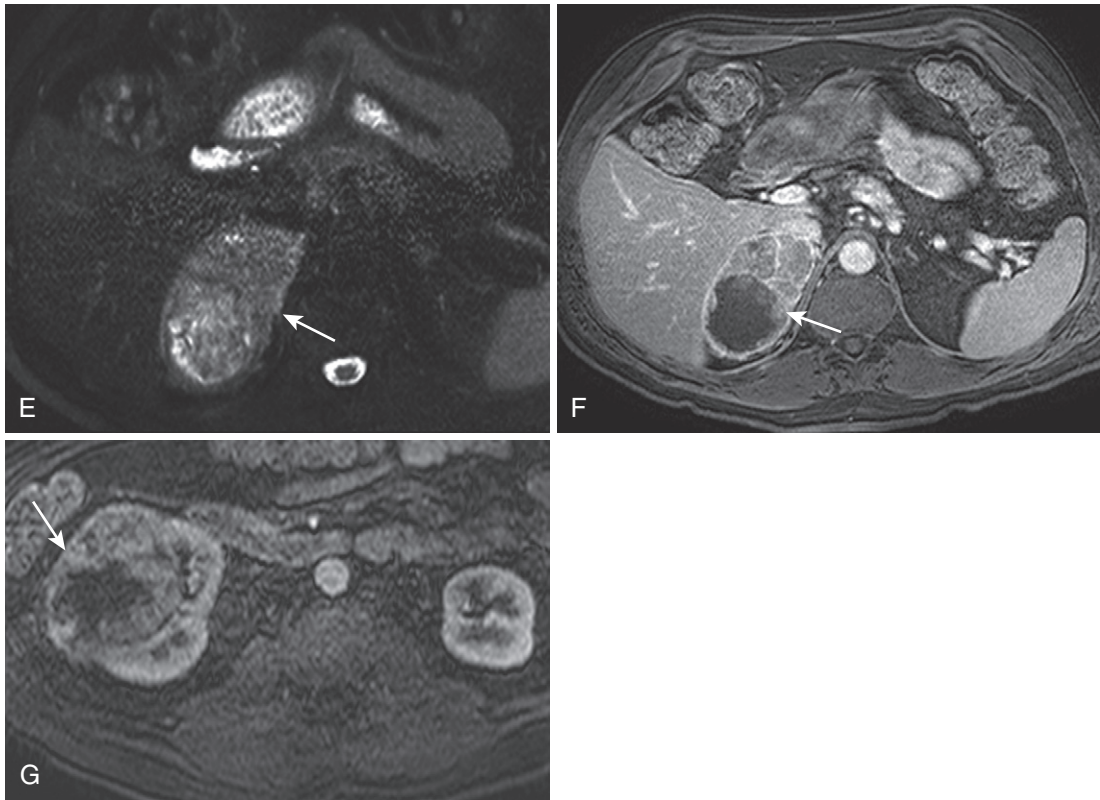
cont'd A large right adrenal mass (arrow in E and F) demonstrates even more heterogeneous signal and enhancement with cystic necrosis on the T2-weighted fat-suppressed (E) and postcontrast (F) images in a different patient with metastatic RCC. G, The primary mass is shown on the postcontrast image through the kidneys (arrow).
